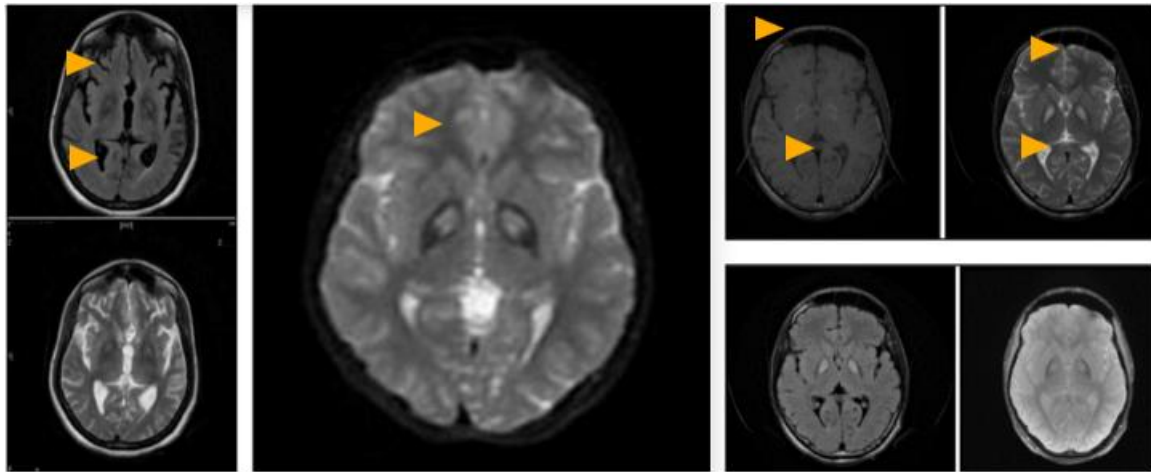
Representative MRI brain showing Eye of Tiger appearance
